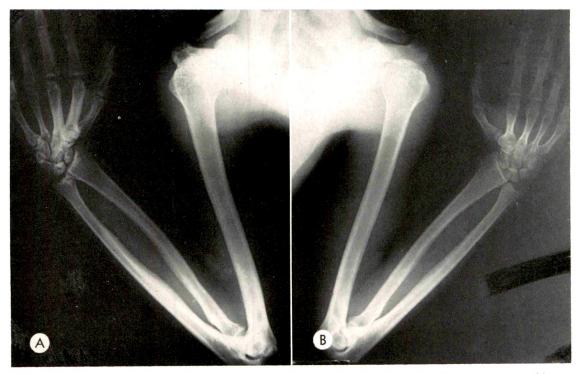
Anteroposterior roentgenogram of both upper extremities demonstrating the roentgenographic appearance of unilateral angiomatosis (A) as compared to the normal side (B). Note the increase in the size of the bones, the thickening of the cortex and the areas of radiolucent sclerotic lesions of the acromion, glenoid fossa and epiphyses of the humerus and radius.
